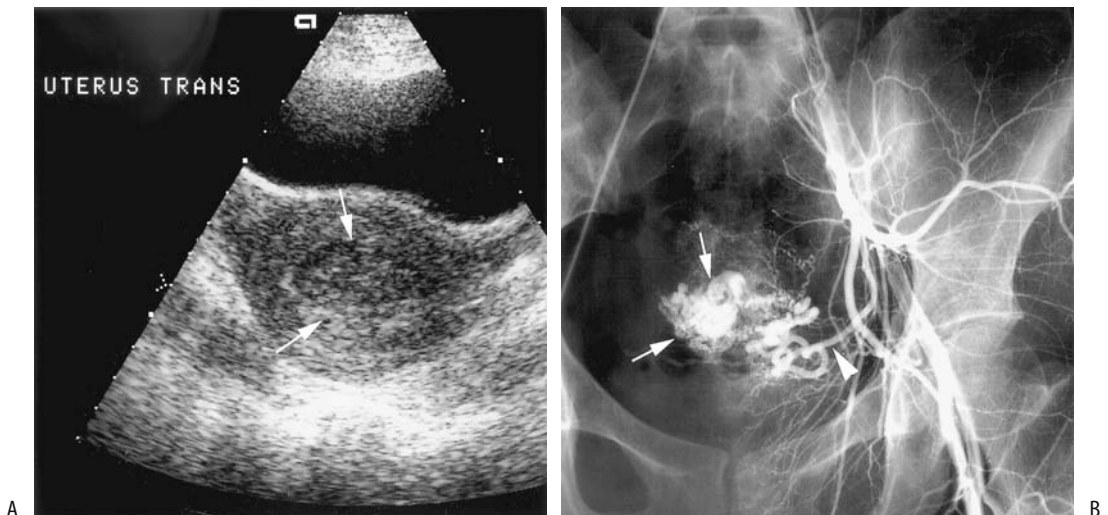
Uterine arteriovenous malformation resulting in vaginal bleeding after dilation and curettage (D&C). A: Transverse gray-scale US reveals a subtle heterogeneous appearance on the left side of the uterus (arrows). Color Doppler US revealed increased blood flow in this region (not shown). B: Arteriography identifies a collection of vessels (arrows) supplied by the left uterine artery (arrowhead); it was embolized with coils. (Source: Kwon JH, Kim GS. Obstetric iatrogenic arterial injuries of the uterus. *Radiographics* 2002;22:35–46, with permission from the Radiological Society of North America.)
